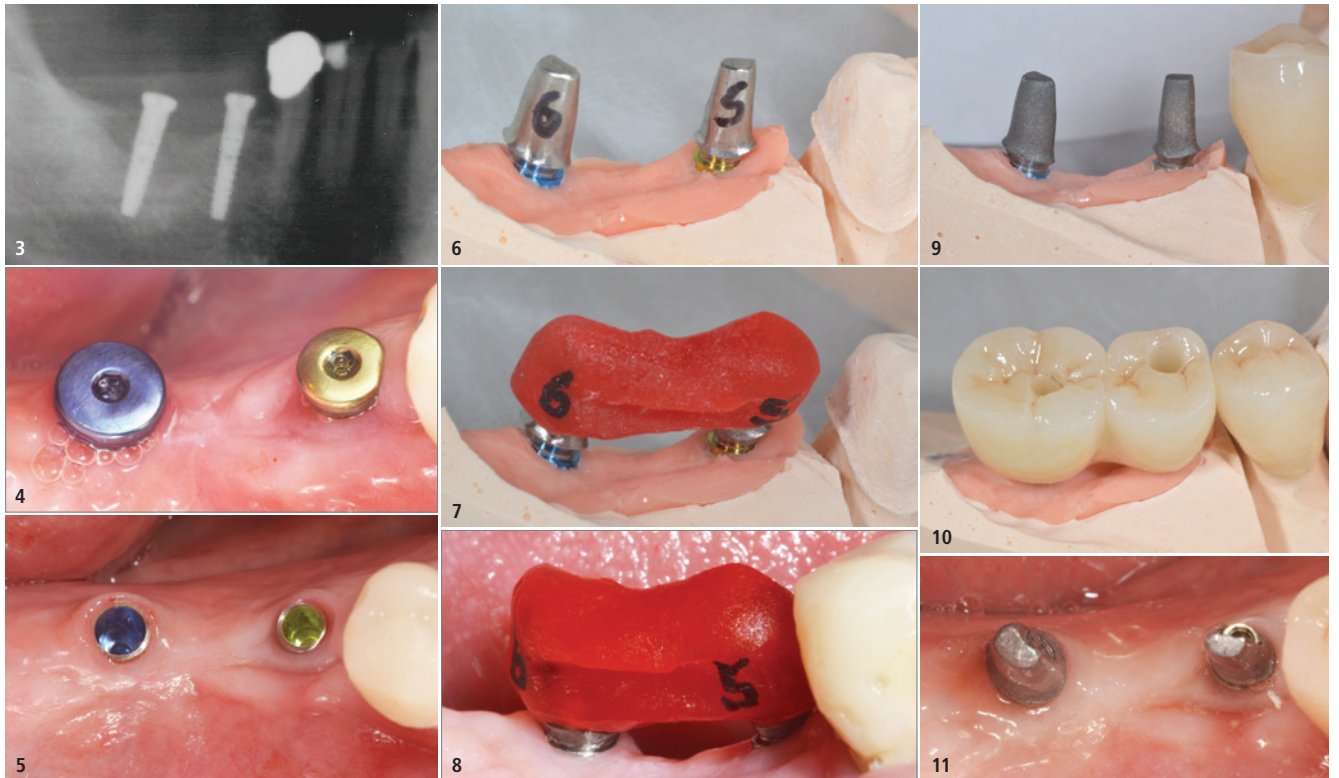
The radiograph control showed that there was sufficient length. – Fig. 4: The healing process was open. – Fig. 5: Clean gingival conditions before open tray impression taking. – Fig. 6: Individualised standard abutments... – Fig. 7: ...with attached implant control splint – Fig. 8: The splint could be fitted tightly, but without tension, intraorally (Labor F. Deinl, Waging am See, Germany). – Fig. 9: The two rough-blasted abutments before intraoral cementation (G-Cem; Fuji). – Fig. 10: Situation, as shown on the master model. – Fig. 11: Abutments after tightening and cleaning.
